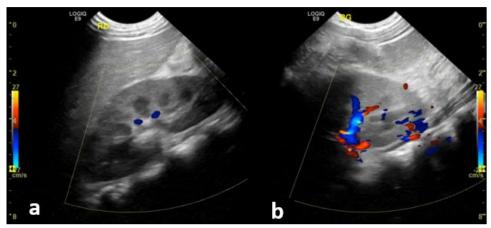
Renal Doppler ultrasound demonstrating markedly reduced intraparenchymal vascular flow in the affected kidney (a), compared to the normal flow in the contralateral kidney (b)
